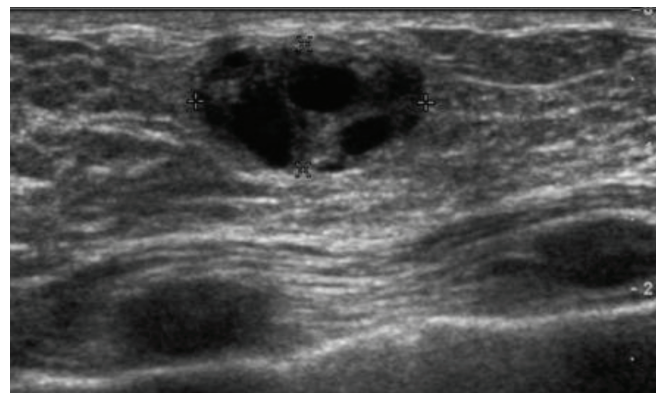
Ultrasound examination of a galactocele
